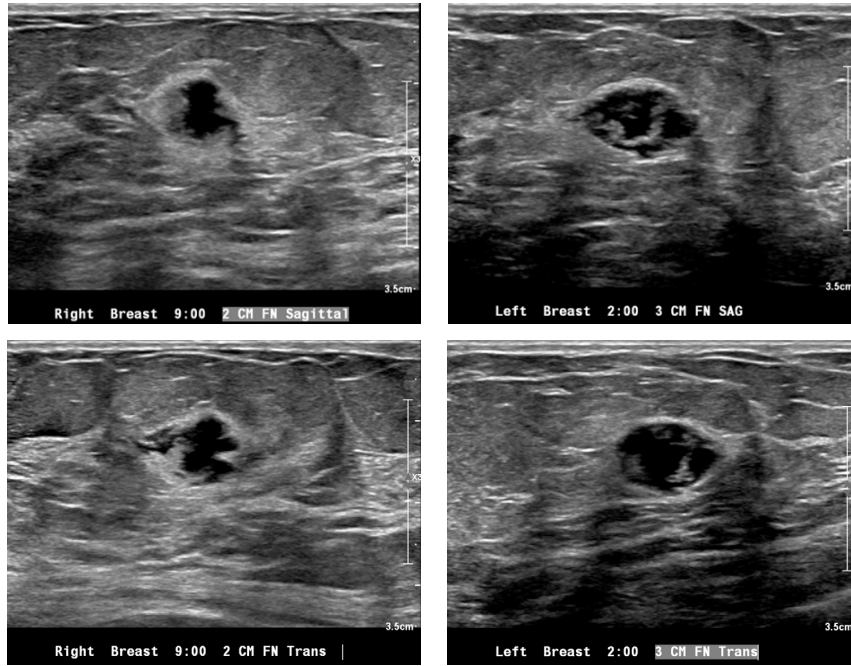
Sagittal and transverse ultrasound images of complex bilateral breast nodules
